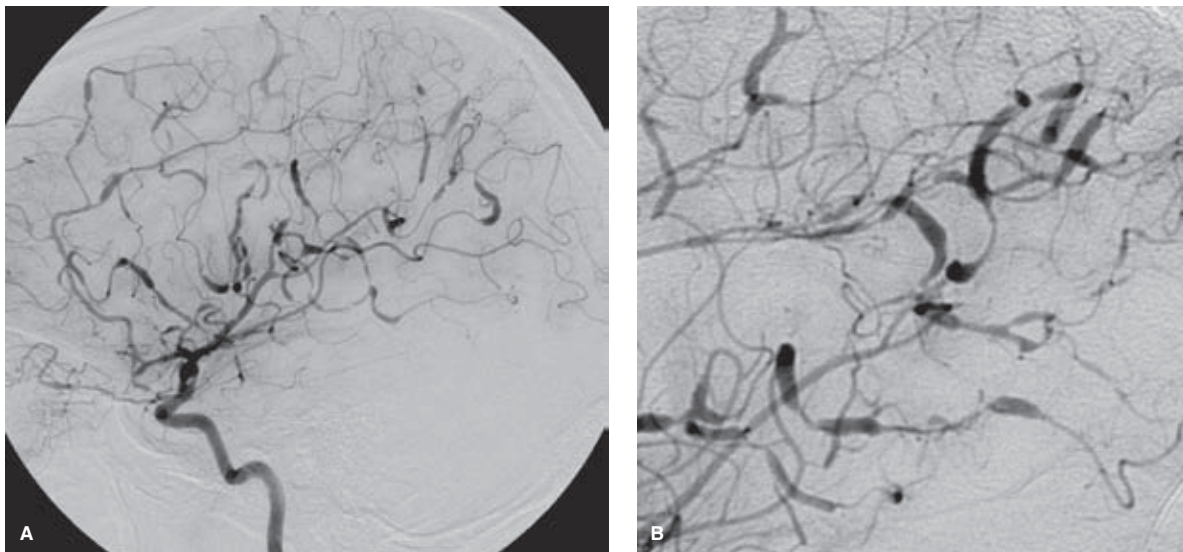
(A–B) HIV-associated arteriopathy. A middle-aged patient with advanced complications of HIV and fluctuating neurologic deficits showed subtle pial enhancement on a gadolinium enhancement MRI (not shown) but no confirming evidence of a meningitis or cerebritis could be found. An angiogram of the left internal carotid artery (A) and magnification view of the right internal carotid artery (B) showed diffuse arterial disease characterized by aneurysmal dilatation of multiple segments of arteries through the anterior circulation. In the absence of an identifiable other cause, this arterial disease was assumed to be a direct effect of the HIV virus itself.
